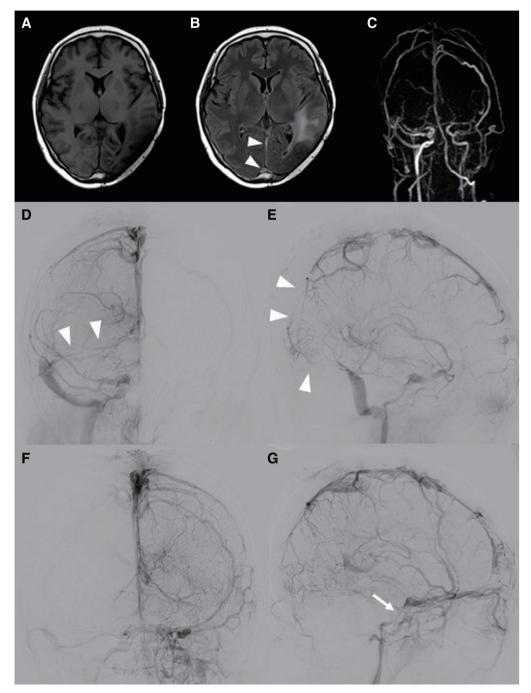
T1-weighted imaging on admission showed no lesions in the dural sinuses (A). However, FLAIR revealed hyper-intensities (arrowheads) in the StS and SSS (B). MRV showed no signal in the SSS and bilateral TS (C). Right internal carotid angiography in the venous phase showed occlusion of the StS, the right TS, and the posterior part of the SSS (arrowheads) (D, E). Left internal carotid angiography showed the patency of left IPS (arrow) (F, G). IPS, inferior petrosal sinus; MRV, magnetic resonance venography; StS, straight sinus; SSS, superior sagittal sinus; TS, transverse sinus
